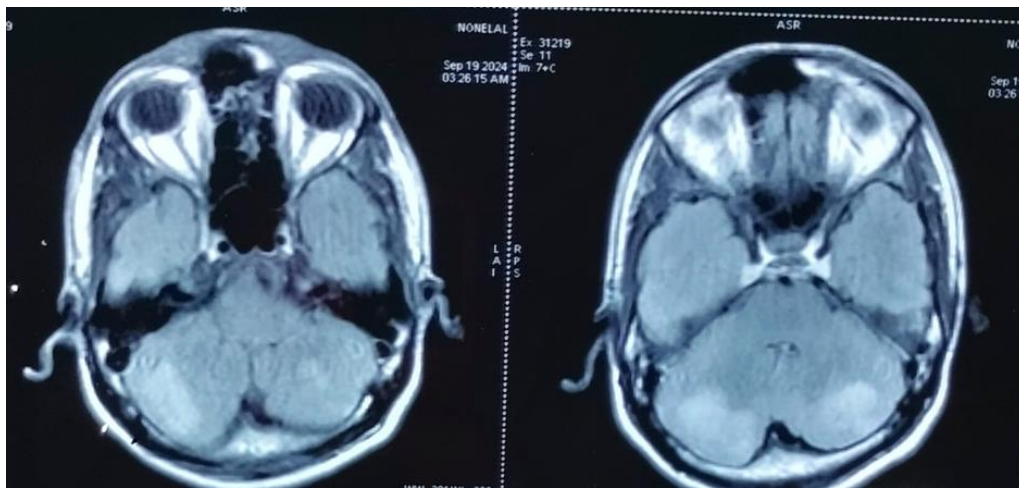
T2 FLAIR image showing hyper intensities over bilateral cerebellar hemispheres
